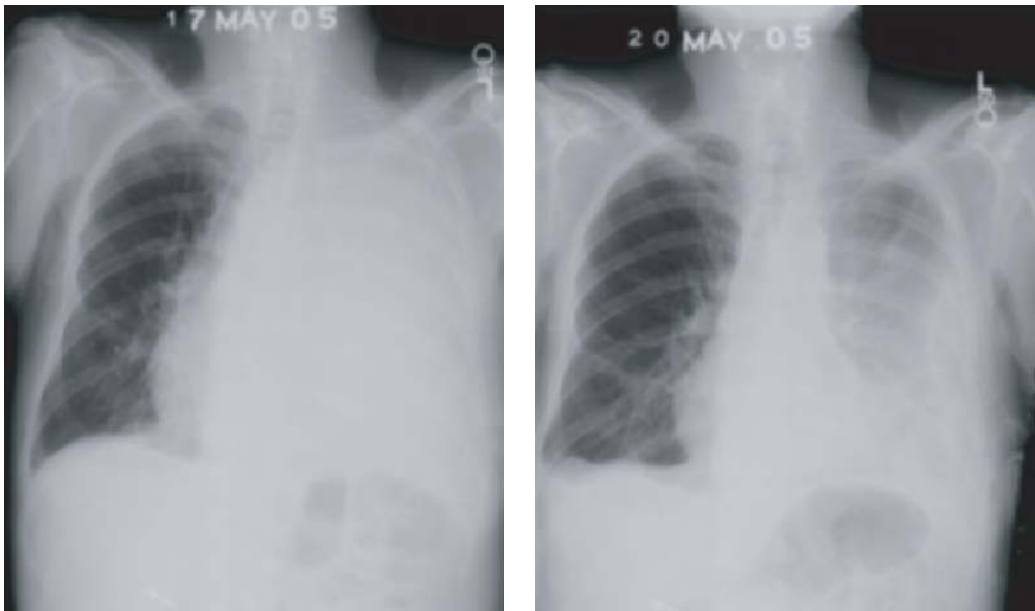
Outpatient management of malignant pleural effusion with tunneled pleural catheter. (a) seventy-eight-year old male with malignant pleural mesothelioma of the left hemithorax with recurrent massive left-sided pleural effusion with contralateral shift of mediastinum and trachea. (b) PA chest radiograph 3 days status post left Pleurx® catheter insertion and drainage of over 3 l of serosanguinous pleural fluid. The patient rapidly achieved near-complete relief of dyspnea and chest discomfort.
